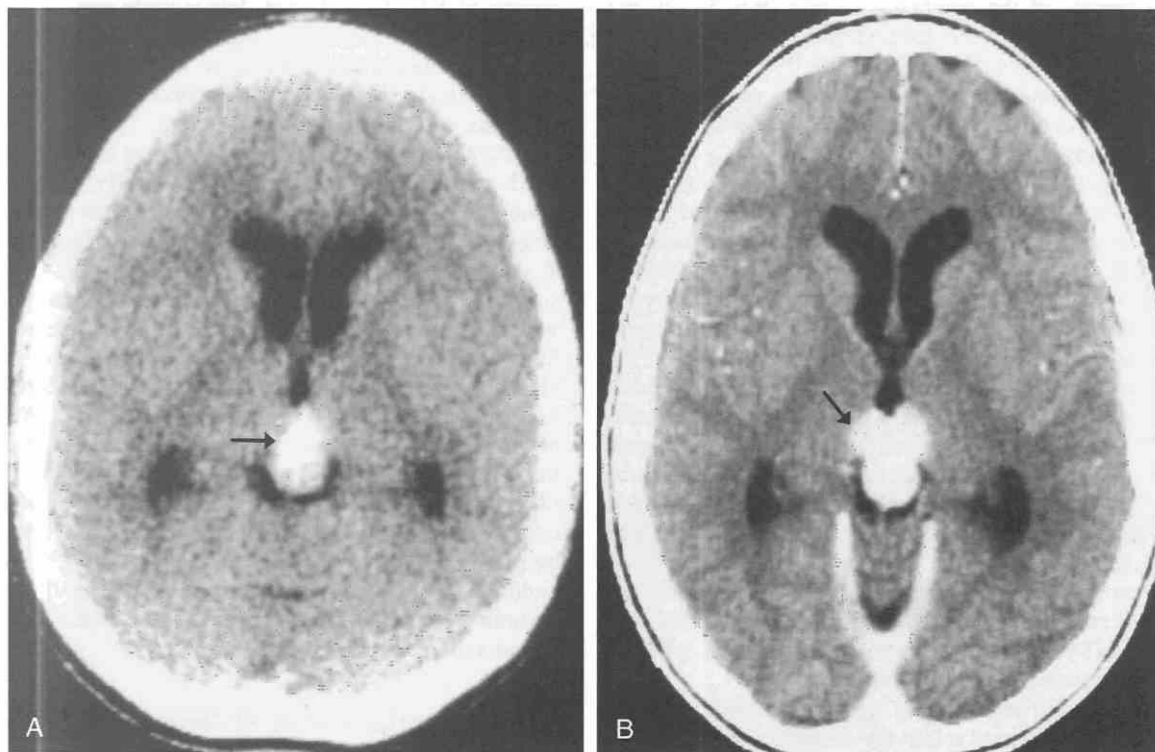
Pineocytoma. Axial noncontrast (A) and postcontrast (B) CT images demonstrate a well circumscribed markedly hyperdense mass in the midline (arrow in A) in the pineal region with bilateral lobulated intense contrast enhancement impinging on the medial aspects of both thalami (arrow in B). The tumor is partially obstructing the posterior aspect of the third ventricle, accounting for the enlarged lateral and anterior third ventricles.
